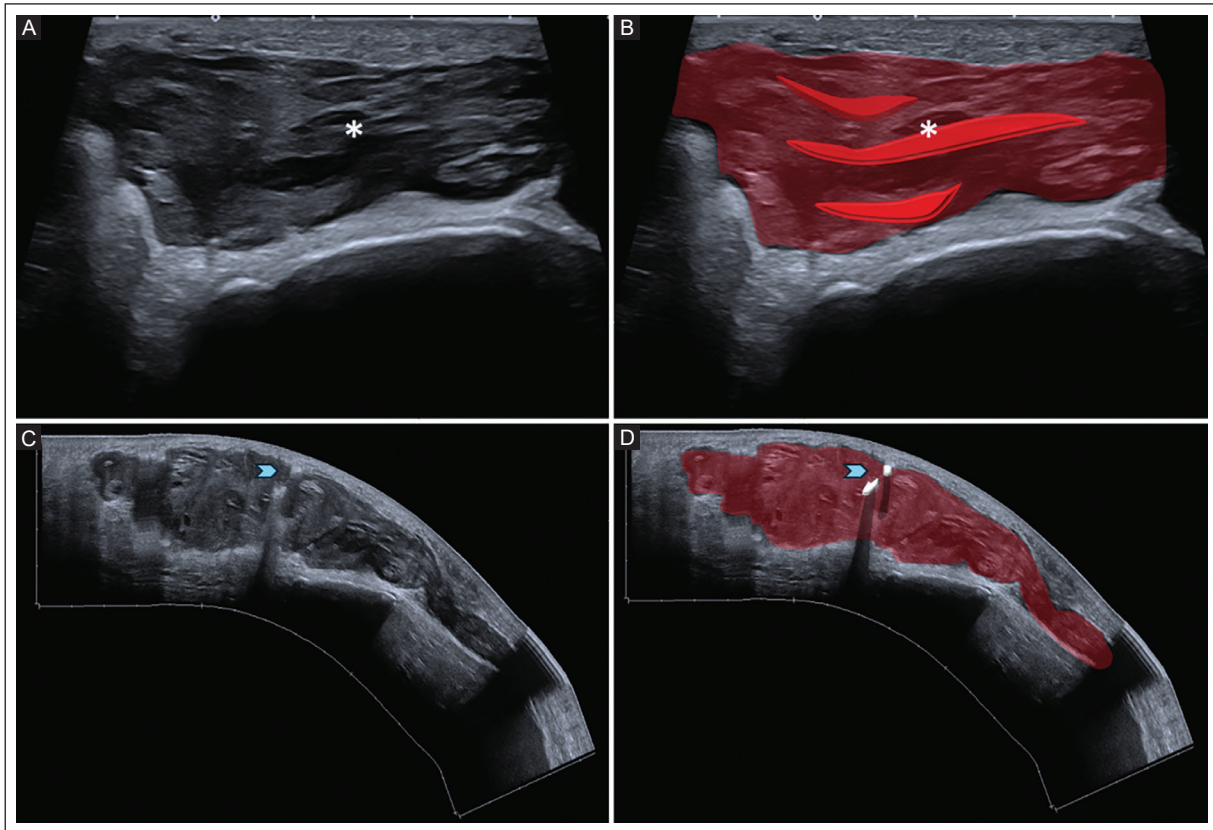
A-B: axial US views of the anterior knee in a 21-year-old woman show hemorragic bursitis with an organized hematoma within the bursa (asterisks), highlighted in red. The lesion shows heterogeneous content and echogenic fragments consistent with debris or hemorrhage, one of the most common ultrasonographic features of acute hemorragic bursitis. C-D: sagittal US images of the anterior knee in a 43-year-old woman show hemorragic bursitis with an organized hematoma highlighted in red, containing internal calcifications highlighted in white (blue arrowheads), findings suggestive of chronicity. In the absence of previous trauma, gout should be considered in the differential diagnosis.
